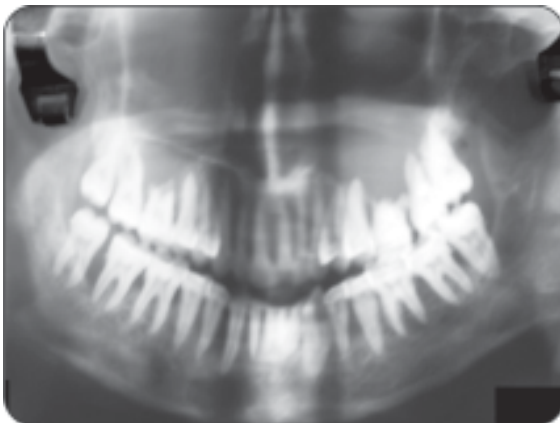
Radiograph of hyperparathyroidism
